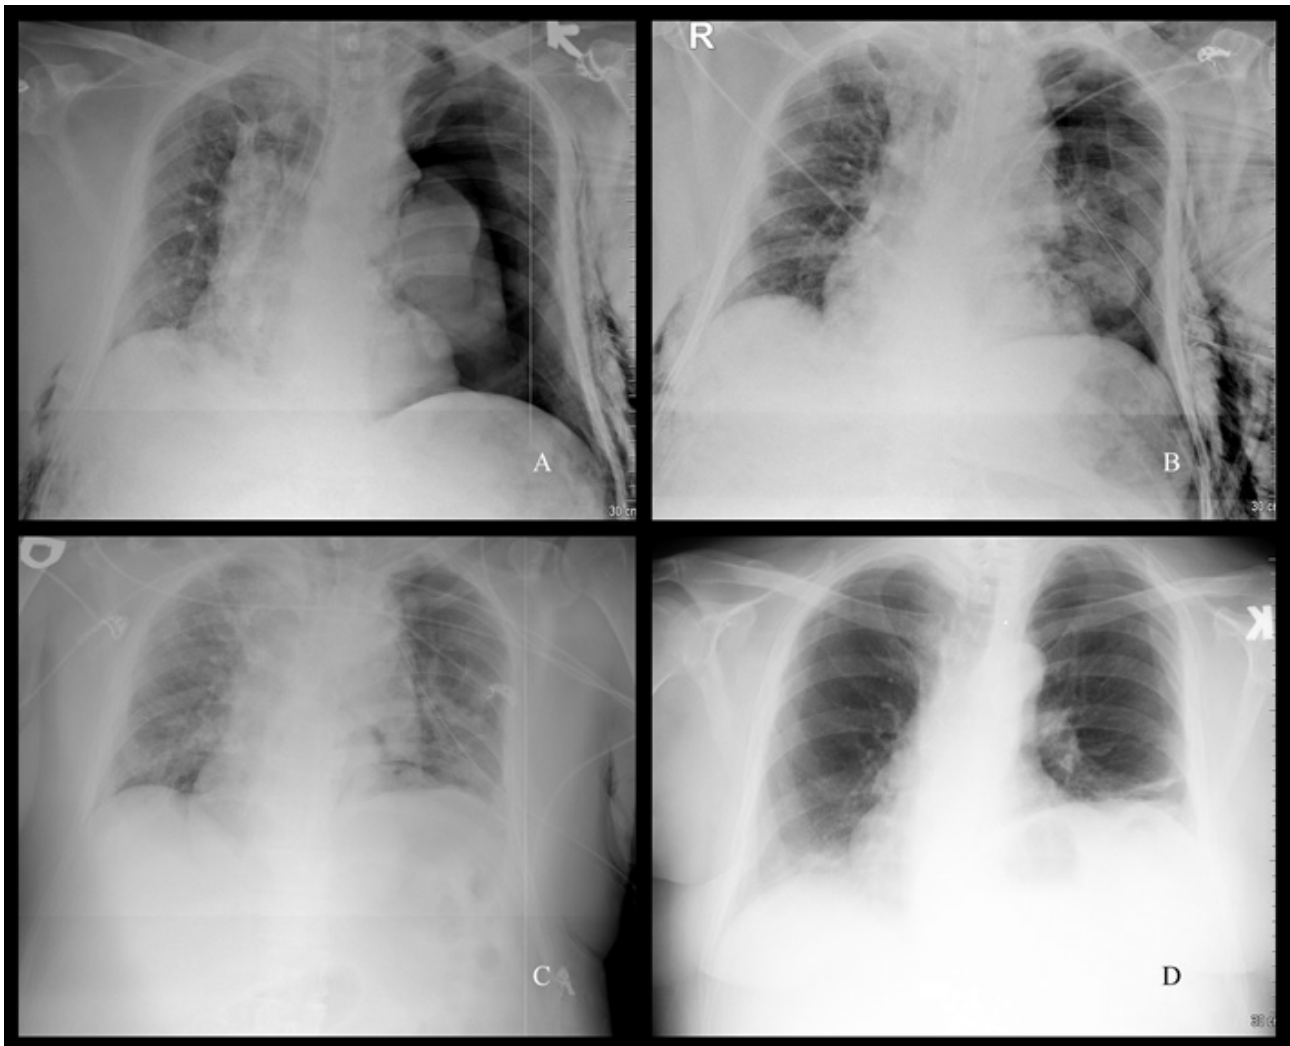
A, B, C - supine, C - erect chest X-rays. A - upon arrival: the patient is rotated to the right, left pneumothorax, collapsed left lung, pronounced subcutaneous emphysema, and endobronchial intubation; B - following drainage: drainage tubes have been inserted into the left pleural cavity, the amount of air has decreased, the left lung has expanded, the endotracheal tube's placement has been corrected; C - after extubation: the left pneumothorax and subcutaneous emphysema have decreased; D - fifteen days after hospitalization: the drainage tube has been removed from the left pleural cavity, a discoid atelectasis and minimal pleural effusion can be seen on the left.
